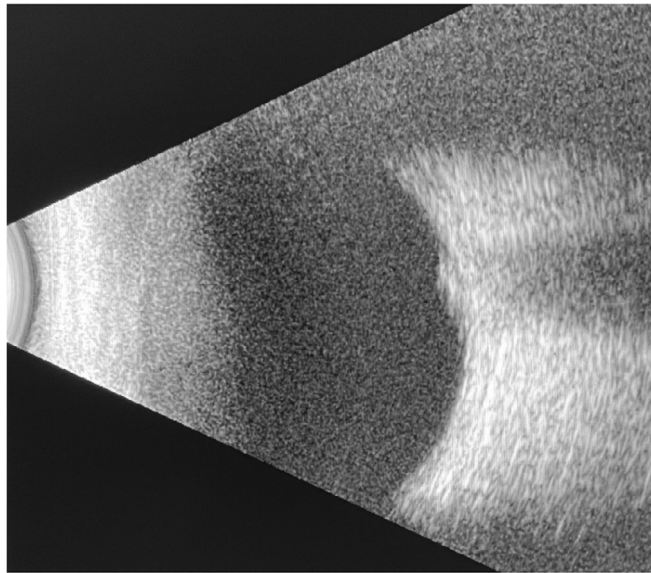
Orbital B-scan ultrasonography of the right eye showing optic disc edema.
